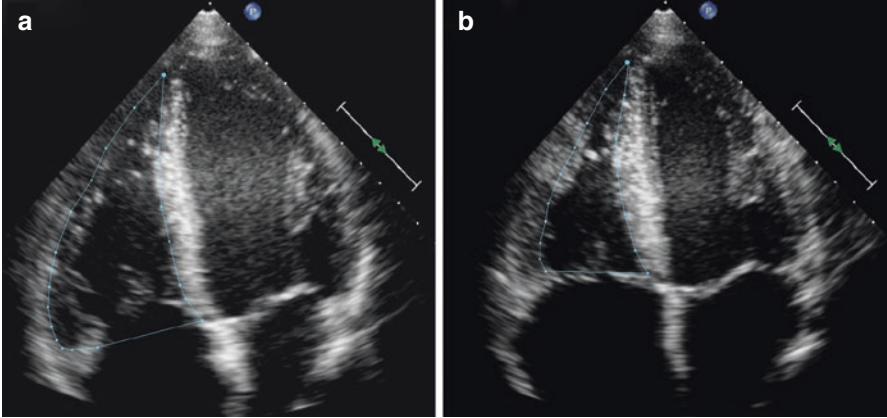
Measurement of RV fraction area change (RV FAC). The endocardial border is traced in the RV focused apical four-chamber views from the tricuspid annulus along the free wall to the apex, then back to the annulus along the interventricular septum. This is performed in end-diastole (a) and systole (b). The RV FAC = (end-diastolic area—end-systolic area/end-diastolic area) × 100%
